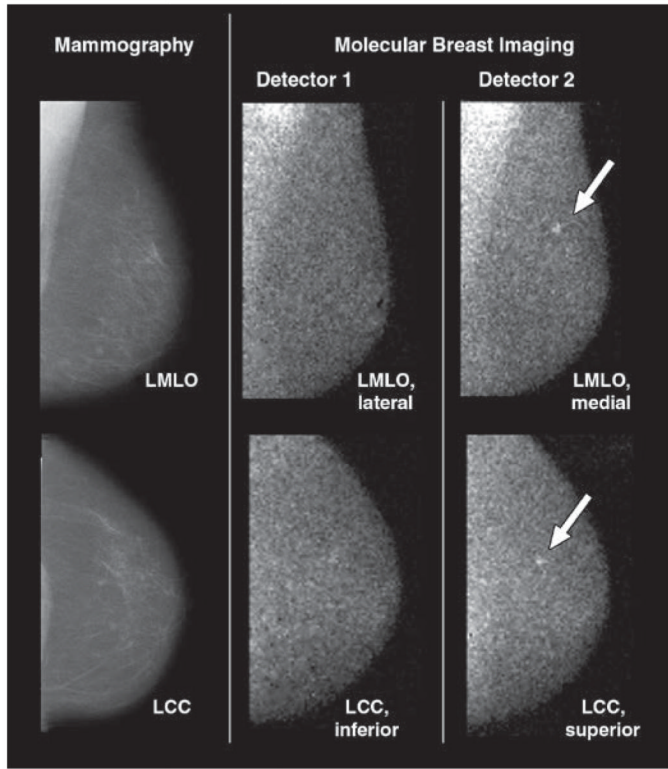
82-year-old woman with 4-mm invasive lobular carcinoma (*arrows*) in upper mid left breast at 12-o'clock position 6 cm from nipple. Cancer was initially identified on mammography as BI-RADS category 5 lesion; 5-mm benign intramammary lymph node in lower inner breast was also identified on mammography and sonography. Screening mammograms and craniocaudal and mediolateral oblique views from both molecular breast imaging detectors are shown. During blinded readings of only inferior and lateral molecular breast imaging views from detector 1 (*middle images*), molecular breast imaging findings were interpreted as negative. When superior and medial views from detector 2 (*right images*) were available for molecular breast imaging interpretation in addition to detector 1 views, cancer was identified and given uptake score of 4 (strong focal uptake) by two readers and score of 3 (moderate focal uptake) by third reader. Findings were otherwise negative on molecular breast imaging. LMLO = left mediolateral oblique, LCC = left craniocaudal.
